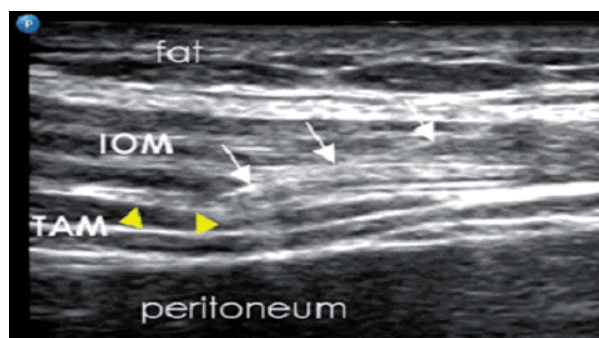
A needle (arrows) inserted in plane with its tip above the IHN (arrowheads) is seen on ultrasound. IOM = Internal oblique muscle; TAM = Transverse abdominis muscle.
